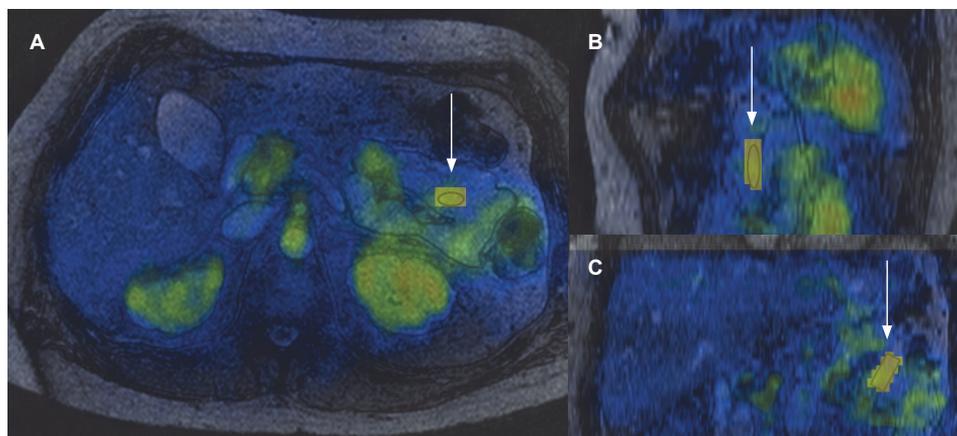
Fused ^{15}O - H_2O positron emission tomography and magnetic resonance images. Cylinder-shaped volume of interest (marked with a yellow arrow) drawn in transaxial (A), coronal (B) and sagittal (C) projections of the small intestine.
